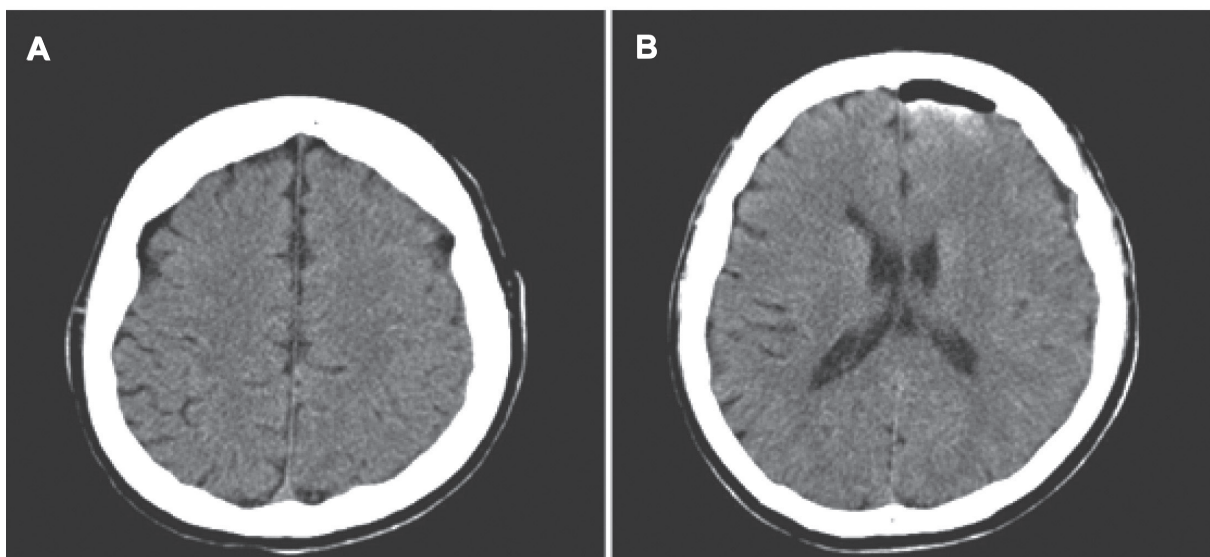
Postoperative brain computed tomography showing (A) no obvious intracerebral hematoma, and (B) minimal pneumocephalus.
